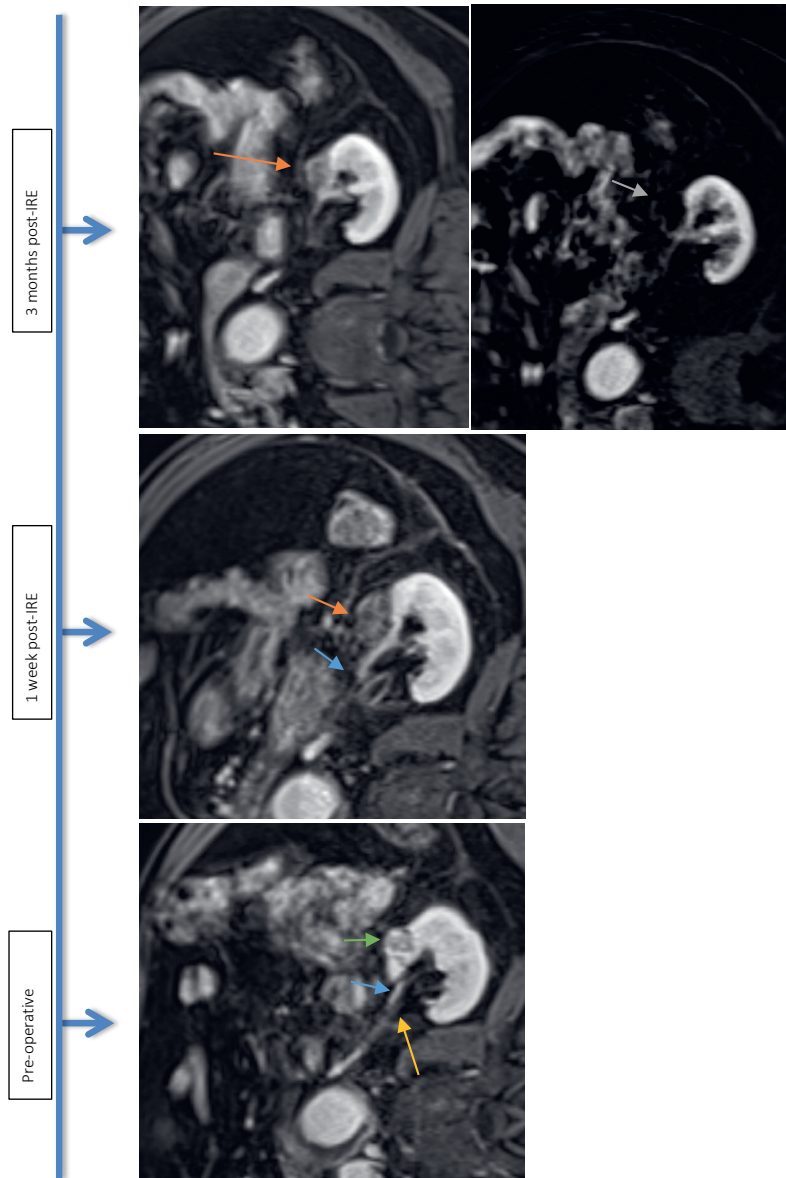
Evolution through time of MRI ablation zone. The lower row of images resemble subtraction images to clarify possible enhancement of the ablation zone seen on post-contrast dynamic images (upper row). From left to right: Tumour pre-IRE (PA: clear cell RCC, volume 3.4 cm³). Notice the proximity of the tumour (green arrow) and the ablation zone post-IRE (orange arrow) to the ureter (yellow arrow) and the renal vasculature of the hilum (blue arrow). 1 week post-IRE ablation zone (volume 11,3 cm³). 3 months post-IRE ablation zone (volume 4,3 cm³). 6 months post-IRE ablation zone (volume 3,6 cm³). 12 months post-IRE ablation zone (volume 1,3 cm³).
